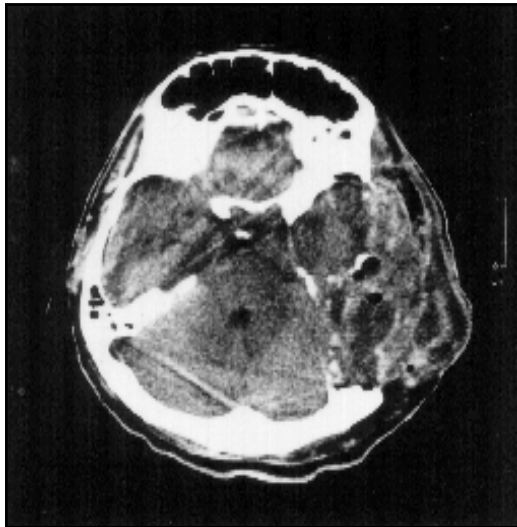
Postoperative axial computed tomography image displaying no residual tumor.
